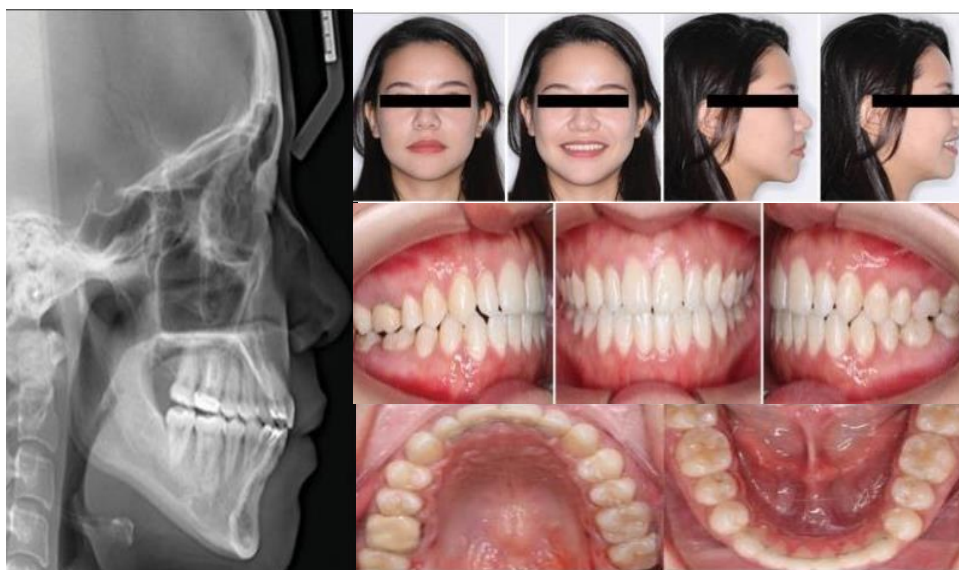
Post treatment radiograph, facial and intraoral photographs (Anh et al., 2023)
